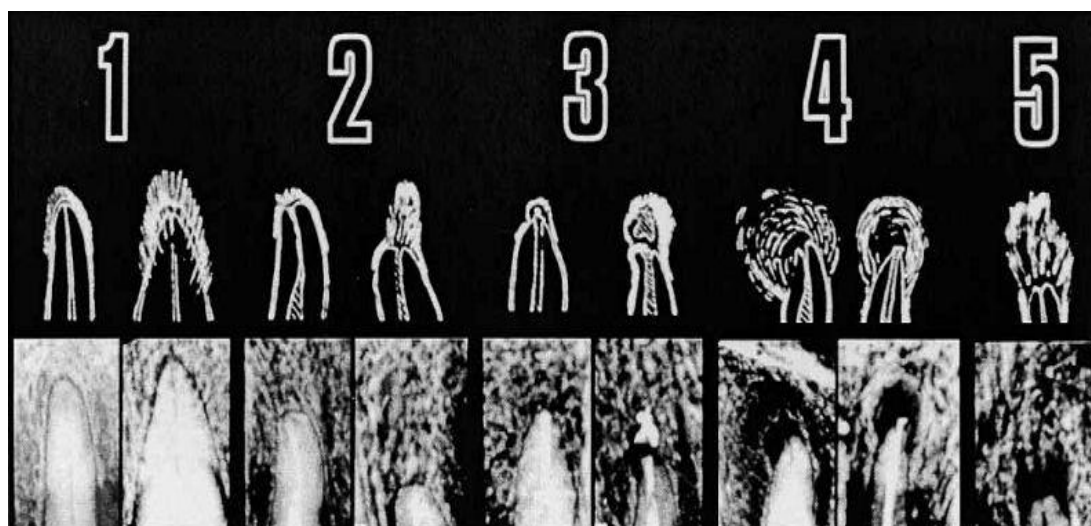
Periapical index scoring criteria (1).
